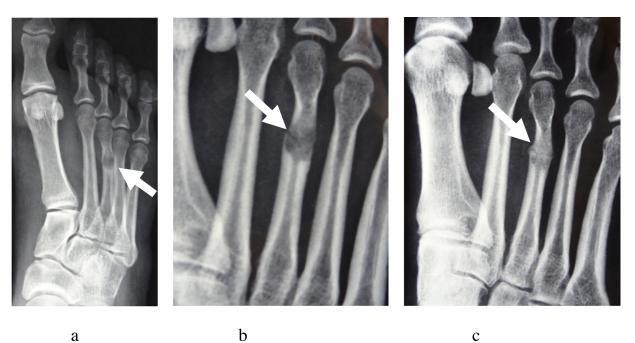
Enchondroma. Radiography (a) shows lucent, well defined lesion (arrow) on distal third of III metatarsus. 45 day later (b) after reported pain, radiography evidenced pathological fracture (arrow). After another 45 days of immobilization (c) occurred consolidation of the lytic lesion and cortex, suggesting healing of the pathological fracture (arrow).
